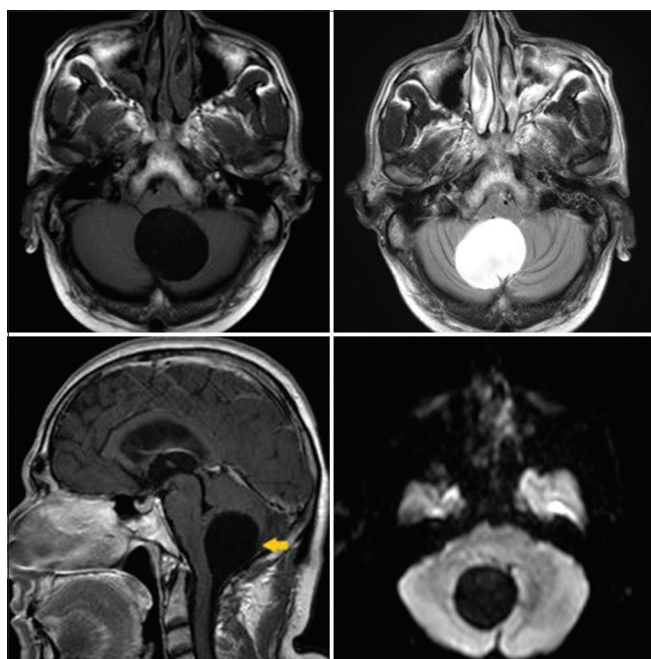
On magnetic resonance imaging a large well circumscribed midline infratentorial cystic lesion appearing hypointense on T1W and hyperintense on T2W with Fluid attenuated inversion recovery suppression, shows no restriction on Diffusion-weighted image and apparent diffusion coefficient mapping which helps to differentiate them from their close differential of an epidermoid cyst. They do not enhance after gadolinium administration
